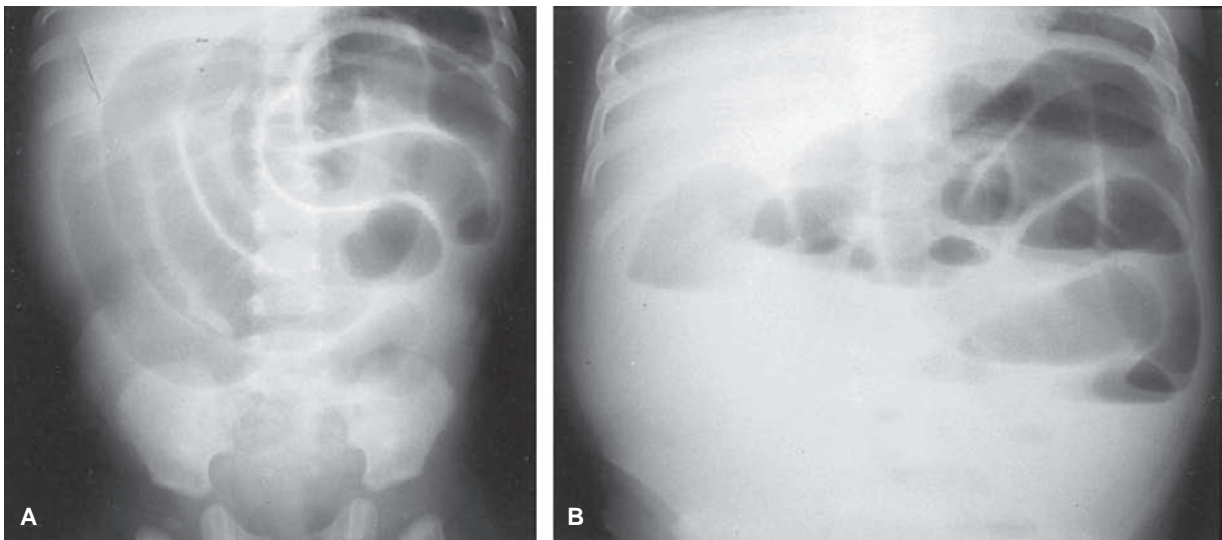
A: Small bowel obstruction. Numerous dilated small bowel loops occupy the midabdomen and have a stepladder configuration. Minimal air is seen in the rectum. B: Same patient as in A. The upright abdominal roentgenogram shows numerous dilated loops in the small bowel with differential fluid levels in one loop indicating mechanical bowel obstruction.
